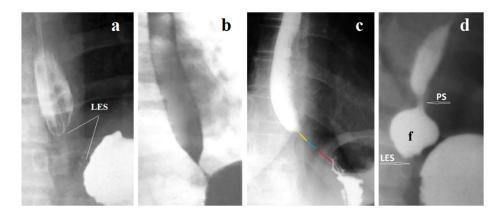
The X-ray image of the LES in GERD can be recorded when the pressure in the stomach is high. (a). The LES is visible during contraction as a zone without contrast agent between the esophagus and stomach. (b). In the presence of inflammation, a contrast agent remains inside the LES. The cone-shaped end of the esophagus above the LES indicates high pressure in the esophagus. (c). In a vertical position, 3 parts of the LES are shown in different colors (above the diaphragm - yellow, inside the diaphragm - blue, abdominal - red). (d). Phrenic ampulla (f) indicates a wide lumen of the esophagus. PS (proximal sphincter) is a functional sphincter that during contraction, closes the ampulla so that when it contracts, it can create high pressure that can open the LES and inject a bolus into the stomach, where the pressure is higher than in the esophagus.
